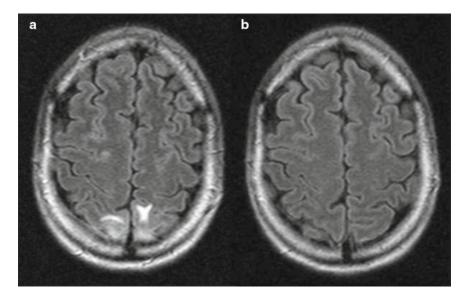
Posterior reversible encephalopathy syndrome (*PRES*) secondary to hypertensive crisis. The patients presented with headaches and binocular visual loss. (a) Axial FLAIR MRI showing white matter hyperintense lesions
